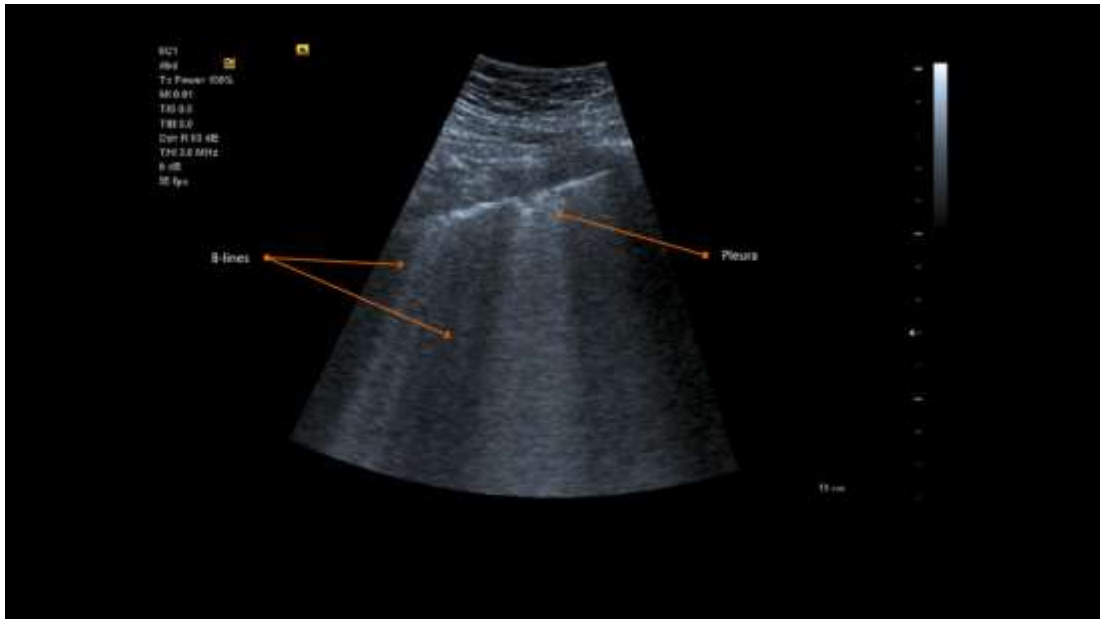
Lung Ultrasound in Patients with Coronavirus COVID-19 Disease (www.siemens-healthineers.com).
